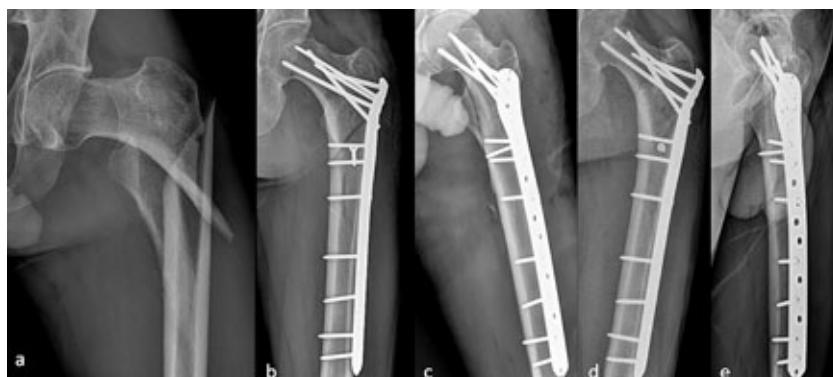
(a) Preoperative X-ray of a 63-year-old male showing an AO 31 A3.3 unstable fracture. (b, c) Early postoperative anteroposterior (AP) and lateral X-rays showing excellent reduction of the fracture. (d, e) AP and lateral X-rays showing union at 15 months postoperatively.
